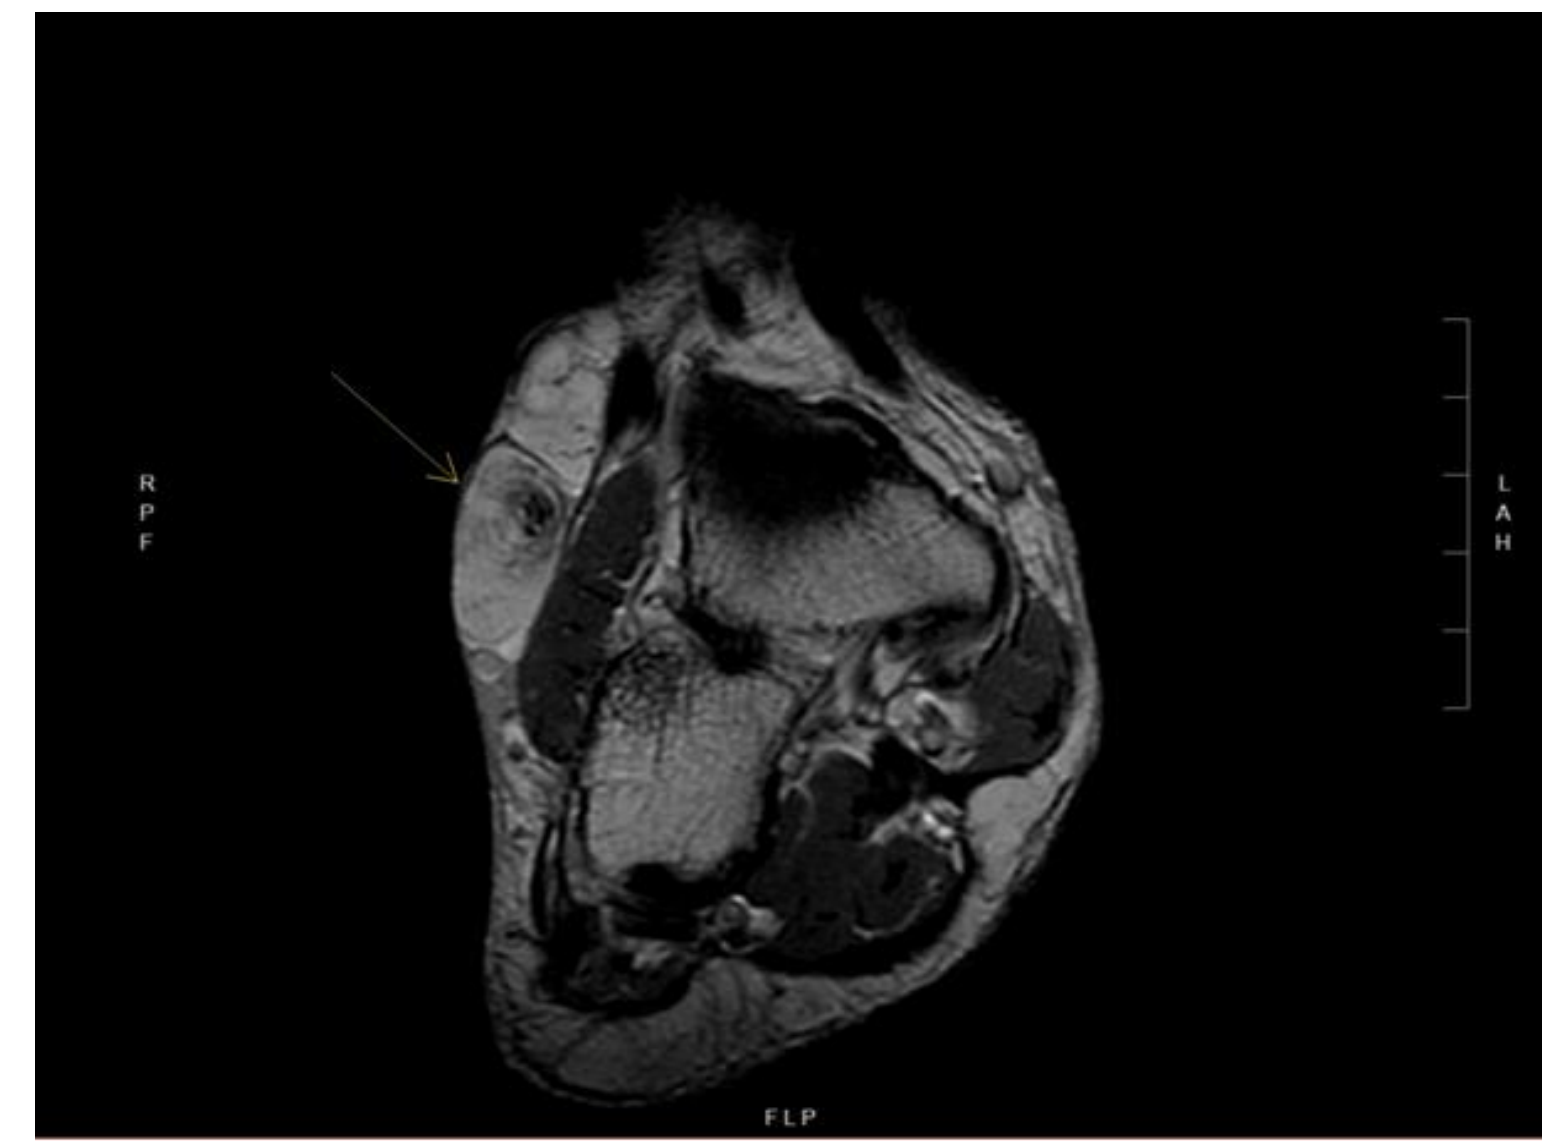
MRI showing a well circumscribed partially encapsulated T1 hyperintense multilobulated mass on the dorsolateral foot.
